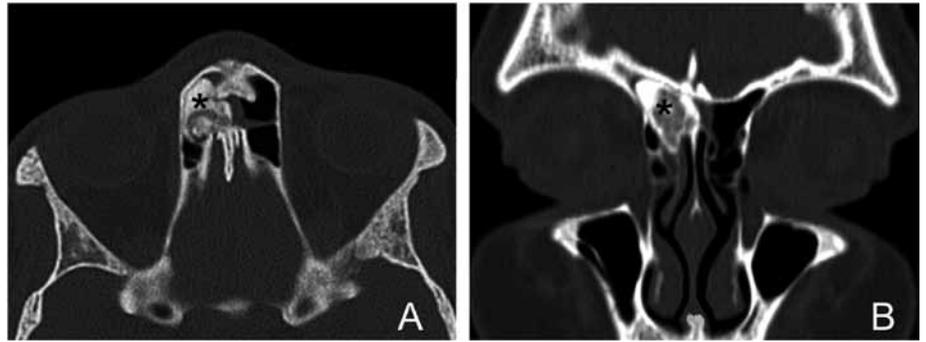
Preoperative CT scan of case 2 shows an osteoma (asterisk) located in the right frontal recess and inserted at the anterolateral aspect of the right cribriform plate. Axial (A) and coronal (B) plane.
